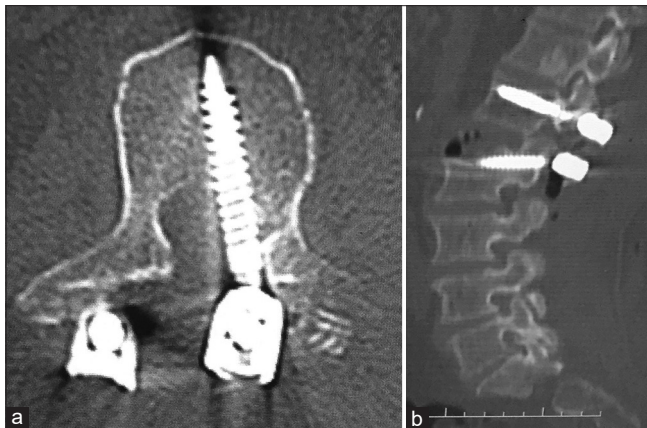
(a) Representative image of an axial computed tomography (CT) scan at L1 spine in a patient operated for fracture dislocation at L1-L2 with complete loss of function below level. Revision surgery was indicated because of direct contact of the hardware with neural elements in the spinal canal. (b) Sagittal reconstruction image of the aforementioned patient.
